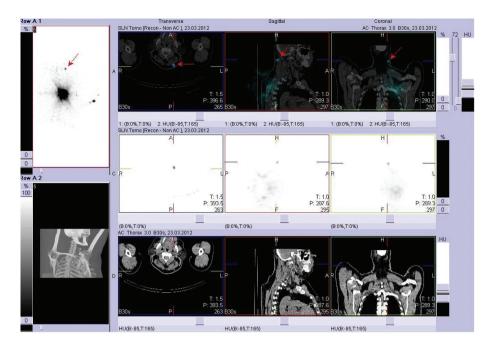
The same patient as in the Figure 1, 2, 3 and 4. Fusion of SPECT and CT. Exact localization of SLN on the left side of the nape
